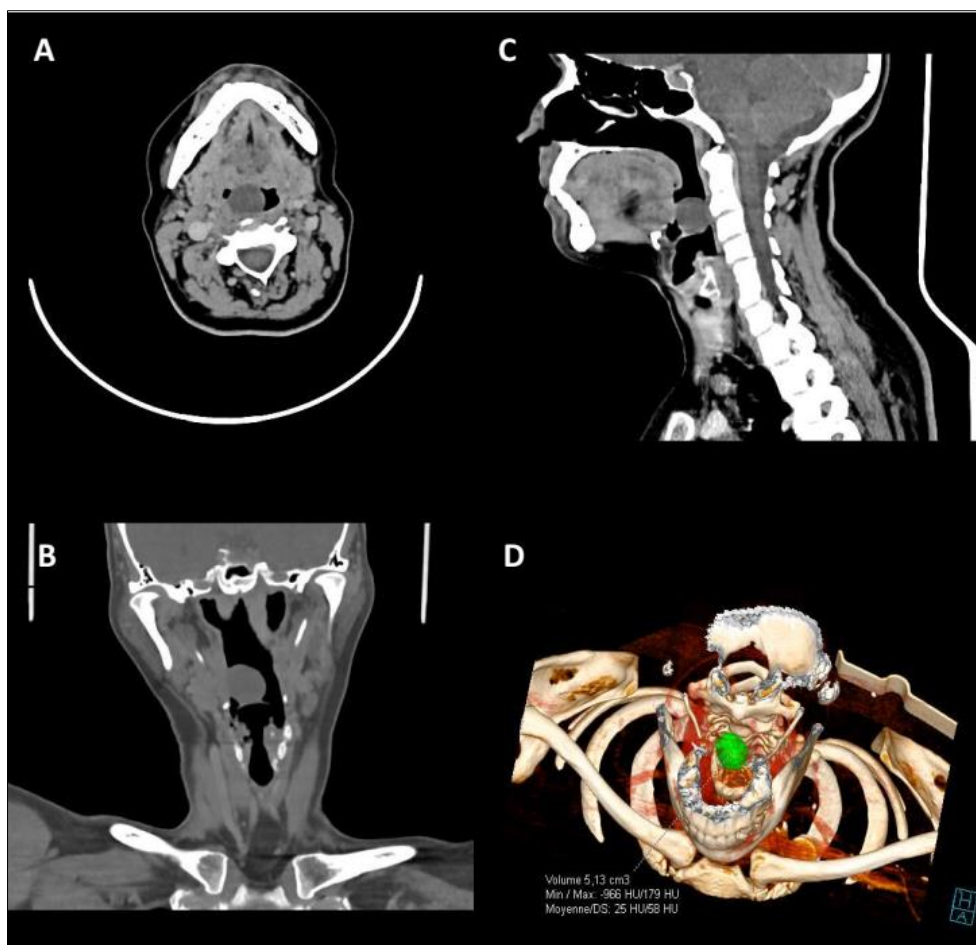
CT scan of the neck (non-contrast), showing an epiglottic cyst in three planes and 3D reconstruction
